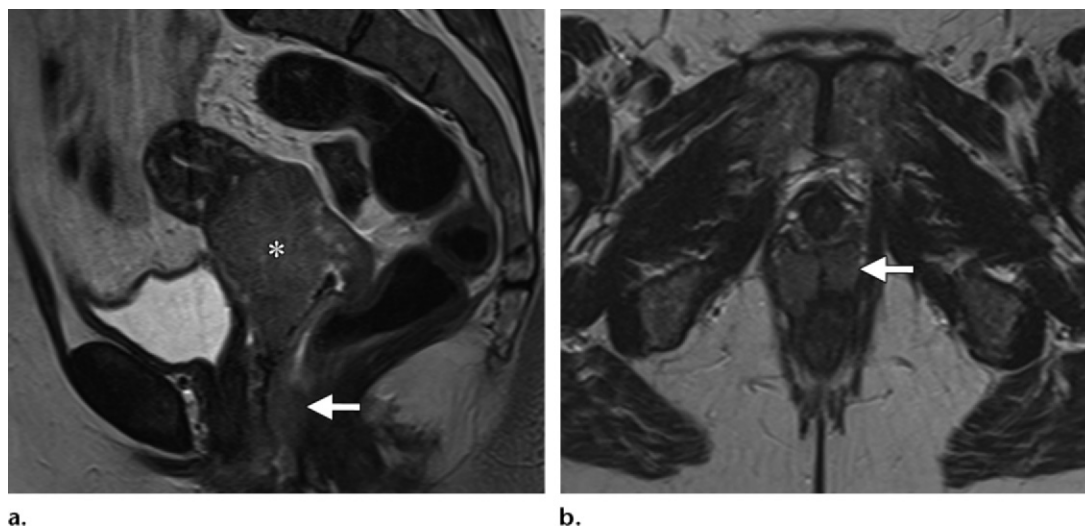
Stage IIIA cervical carcinoma (squamous cell carcinoma) in a 61-year-old woman. Sagittal (a) and axial (b) T2-weighted MR images show a bulky cervical tumor (*) with intermediate signal intensity extending into the lower one-third of the vagina (arrow).
